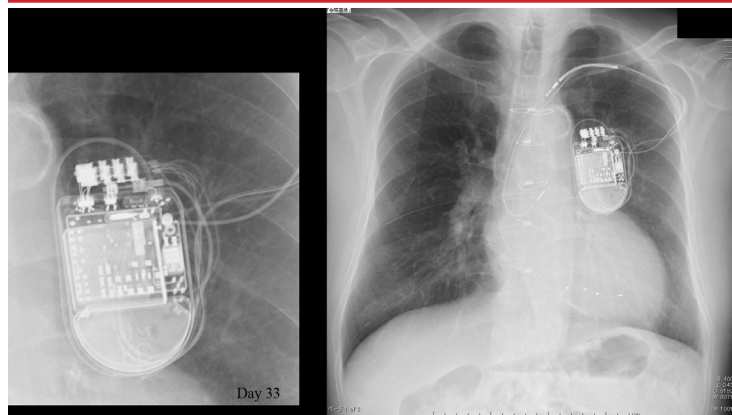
Chest X-ray showed shock lead dislodgment at 33 days after implantation. The shock lead tip was in the left subclavian vein, while the other leads and pulse generator remained in the original positions
